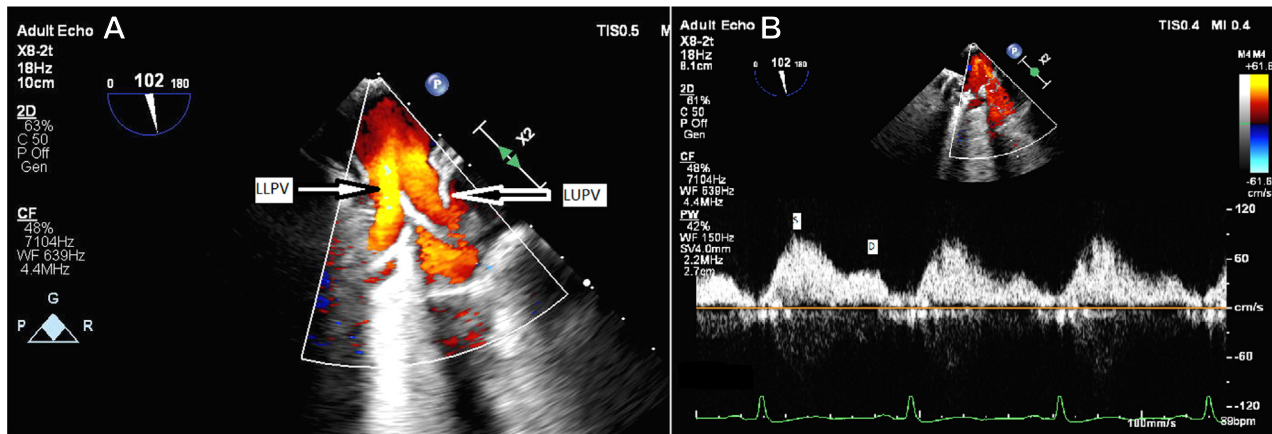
Two-dimensional TEE, midesophageal long-axis (102°) view with (A) color flow Doppler and (B) pulsed-wave Doppler, demonstrates the normal left pulmonic venous drainage into the left atrium. D, Diastolic flow; LLPV, left lower PV; LUPV, left upper PV; S, systolic flow.
